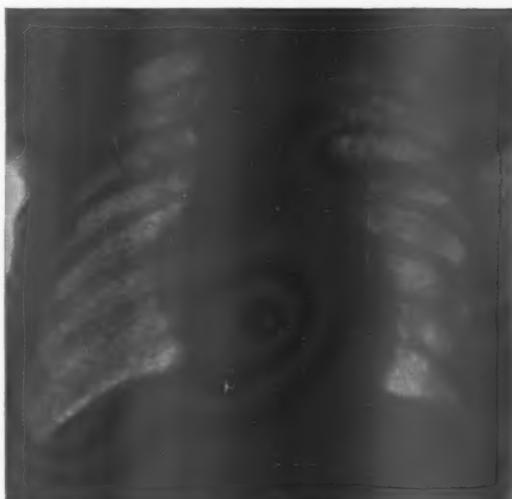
Radiograph, Case I, two months after operation.
